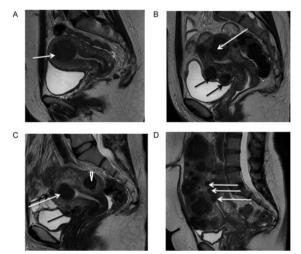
Magnetic resonance imaging of fibroids. Midline sagittal T2-weighted images show different types of myomas according to the FIGO classification. Fibroids vary in size, number and site in the uterus. (A) Submucosal type 2 myoma. (B) Large type 2–5 myoma (white arrow): submucosal and subserosal, each with less than half the diameter in the endometrial and peritoneal cavities respectively. Subserosal type 5 myomas (subserosal, >50% intramural) (black arrows). (C) Submucosal type 2 myoma (>50% intramural) (white arrow). Intramural type 4 myoma (arrowhead). Small type 5 myomas (black arrows). (D) Multiple myomas, three of which are type 0 (intracavitary) (white arrows).
